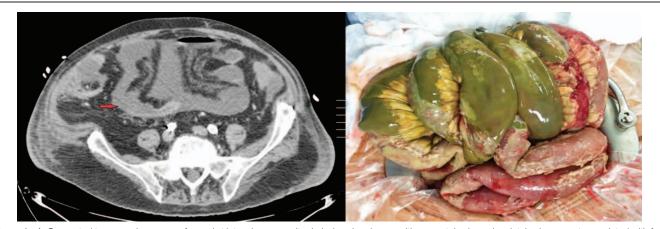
A, Computed tomography scan performed at intensive care unit admission showing a multisegmental enlarged parietal enlargement associated with free peritoneal effusion in the process of partitioning. B, Exploration of the abdominal cavity by laparotomy, showing a severe mesenteric infarction with peritonitis.
